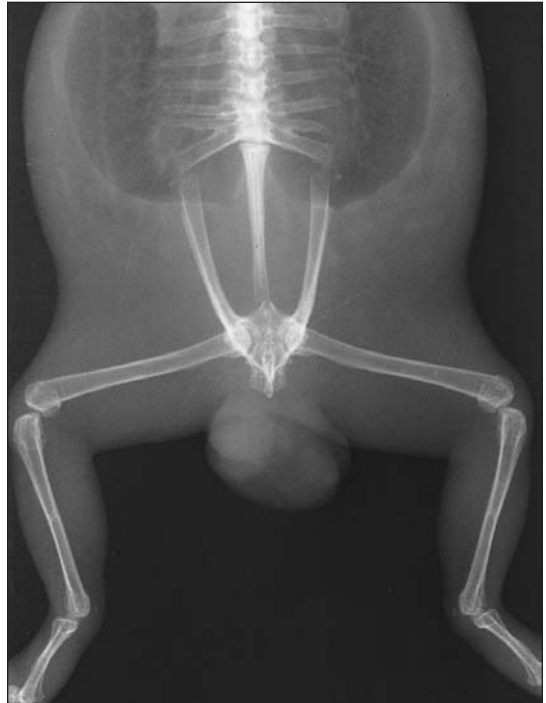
Lateral horizontal beam (left) and dorsoventral (right) radiographic views of a mature male South African bullfrog evaluated because of a cloacal mass.
